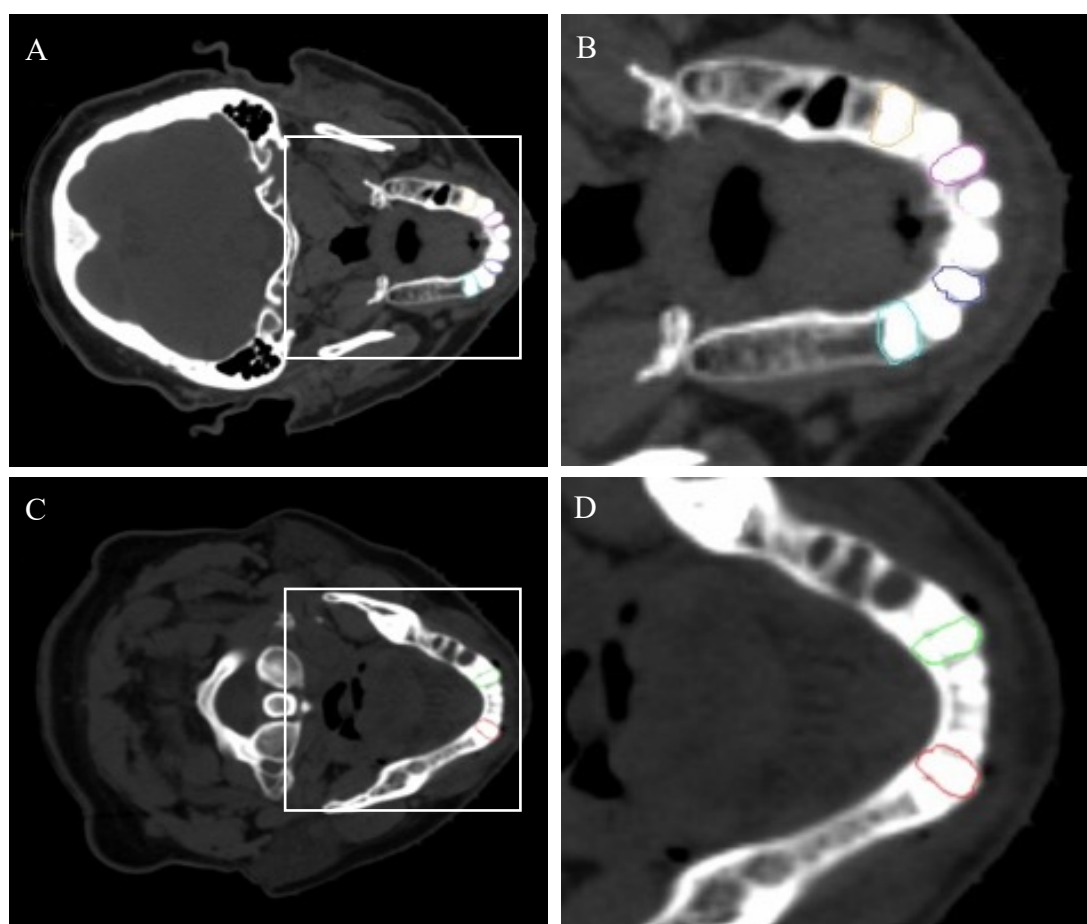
CT scan axial view for the maxilla (A) and mandible (C). Images B and D are zoomed images of the jaws showing the contouring of the teeth for patient 11.
